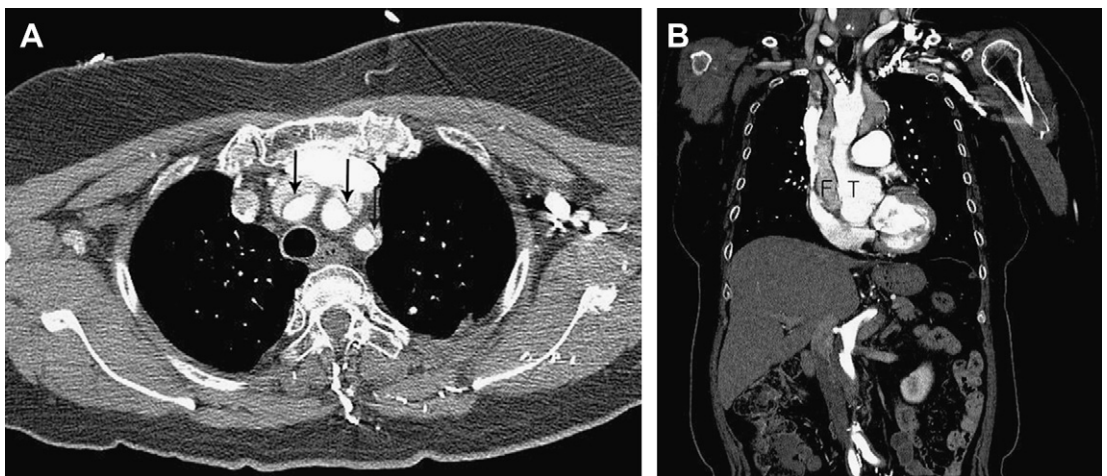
Extension of intimomedial flap into all of three aortic arch branches in 67-year-old woman with Stanford type A aortic dissection. (A) Intimomedial flap (arrows) is noted in brachiocephalic, left common carotid, and left subclavian artery on contrast-enhanced axial CT image at the level of left brachiocephalic vein. (B) Intimomedial flap (arrows) extending into brachiocephalic artery is clearly noted on coronal MPR image. The contrast enhancement of true lumen (T) is higher than that of false lumen (F) owing to slow flow of the false lumen.
